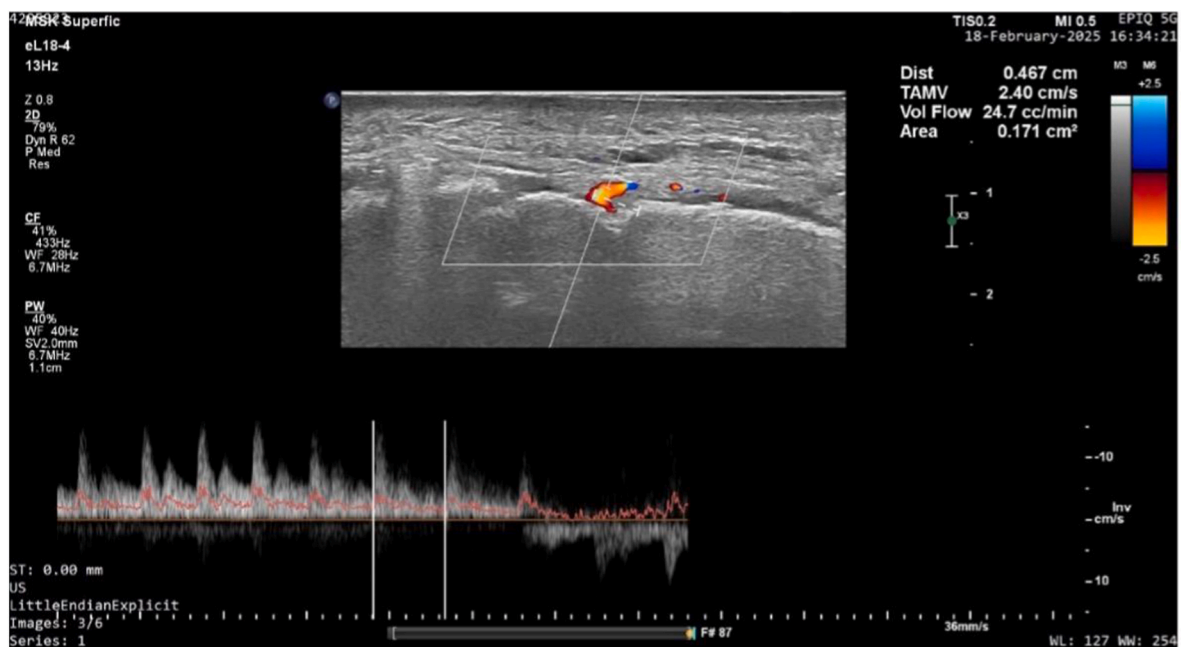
Spectral and color Doppler ultrasound image showing the flow velocity within the mental foramen. Time-averaged mean velocity (TAMV) = 2.40 cm/s; volume flow = 24.7 cc/min; mental foramen diameter = .467 cm; cross-sectional area = .171 cm².
